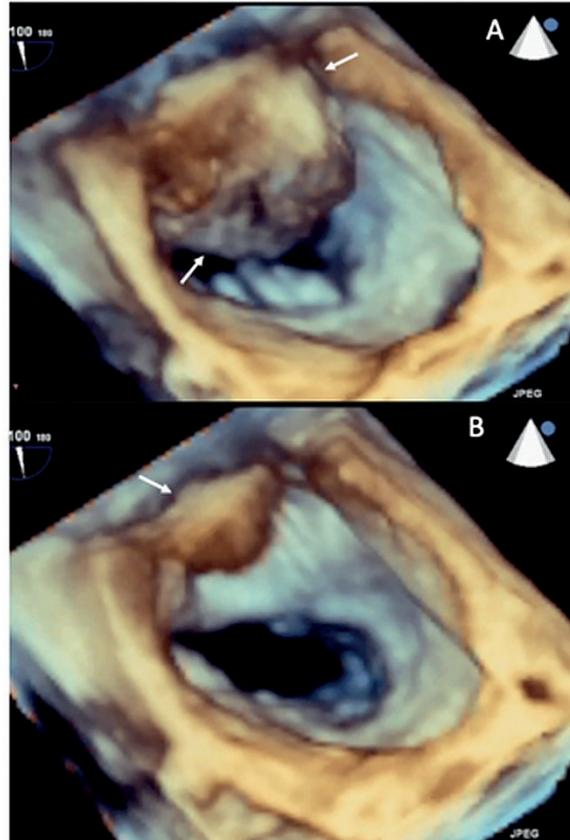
Transoesophageal 3D echocardiography in the surgeon view with a pseudo-cavity inside the left atrium appearing and disappearing (white arrows) in relation to the cardiac cycle (A) and comprising the postero-medial segment of the mitral annulus (white arrows), (B).
